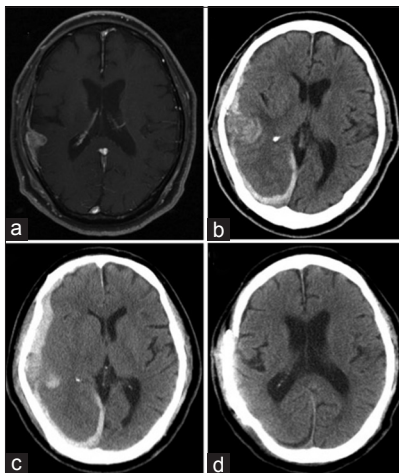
(a) A gadolinium-enhanced T1-weighted magnetic resonance (Gd-T1WI MR) image taken before scheduled surgery revealed the contrasted mass lesion on the left calvarium adjacent to normal brain with subdural invasion. (b) Head computed tomography (CT) taken on the day of admission revealed right-sided acute subdural hematoma (SDH). (c) Head CT performed before the urgent surgery revealed acute SDH with midline shift that indicated intratumoral hemorrhage of the calvarial metastasis. (d) Postoperative head CT showed the resected calvarial tumor and improvement of the midline shift
